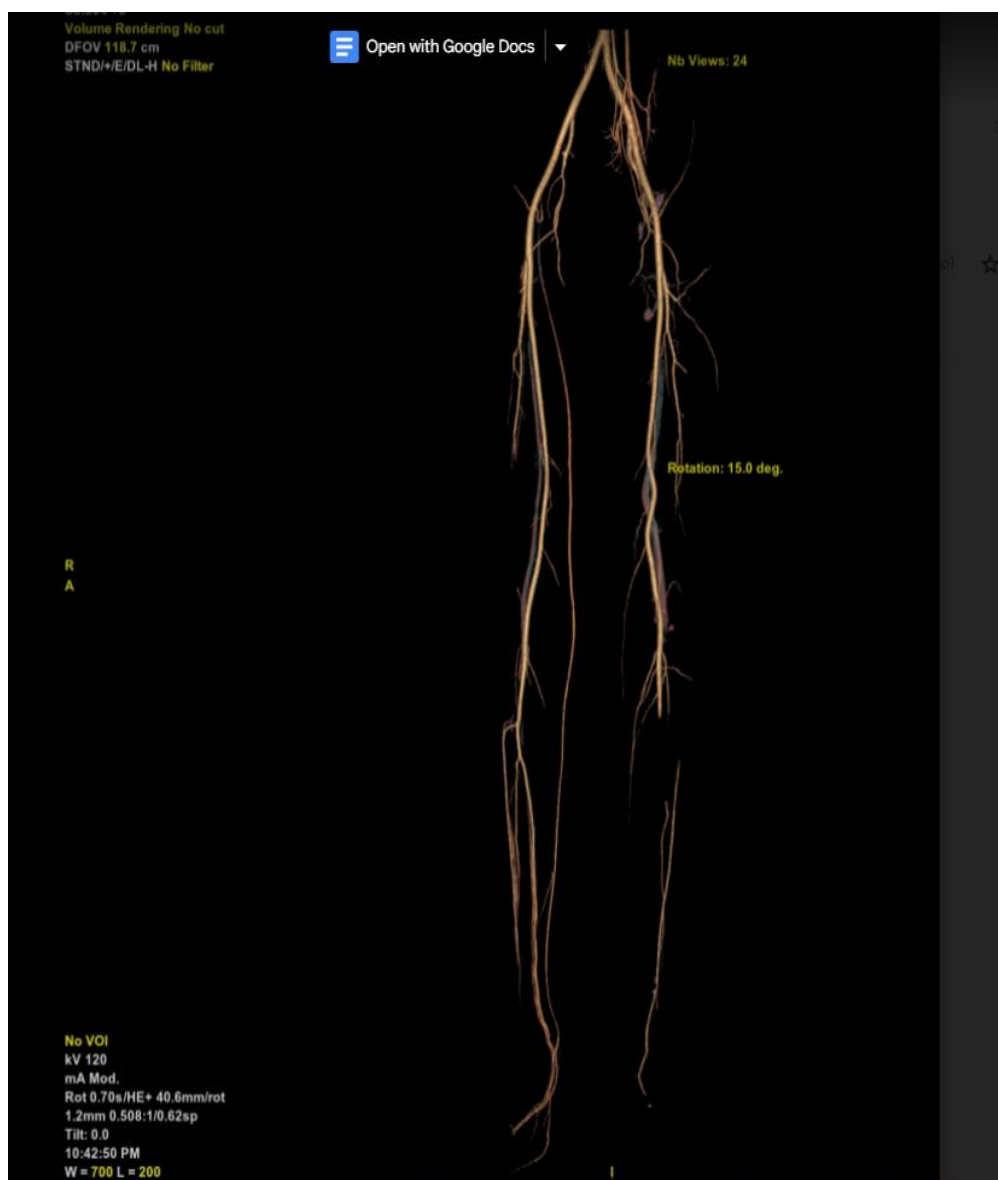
Emergency CT-A femoral run off revealed total occlusion of distal left popliteal, anterior tibial, posterior tibial, and peroneal arteries.
